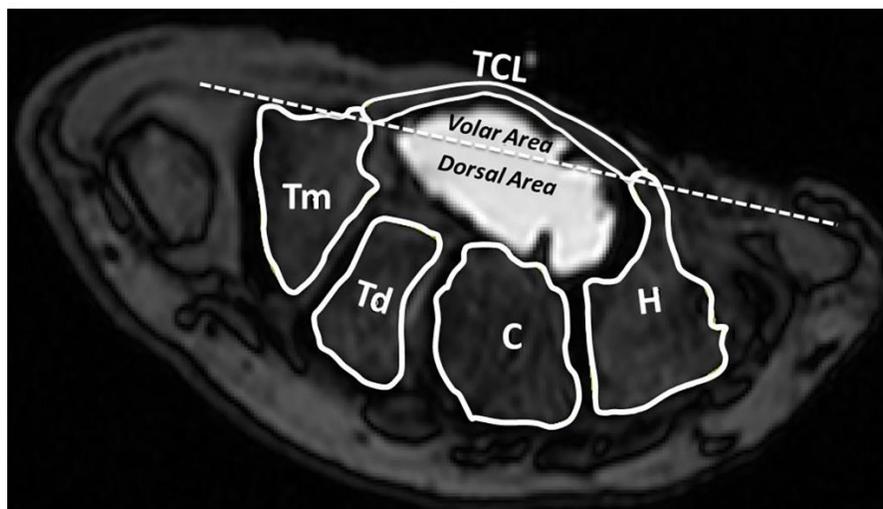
Magnetic resonance imaging segmentation of the four distal carpal bones and the transverse carpal ligament (TCL). Tm = Trapezium, Td = Trapezoid, C= Capitate, H = Hamate, and TCL = transverse carpal ligament. [16]
